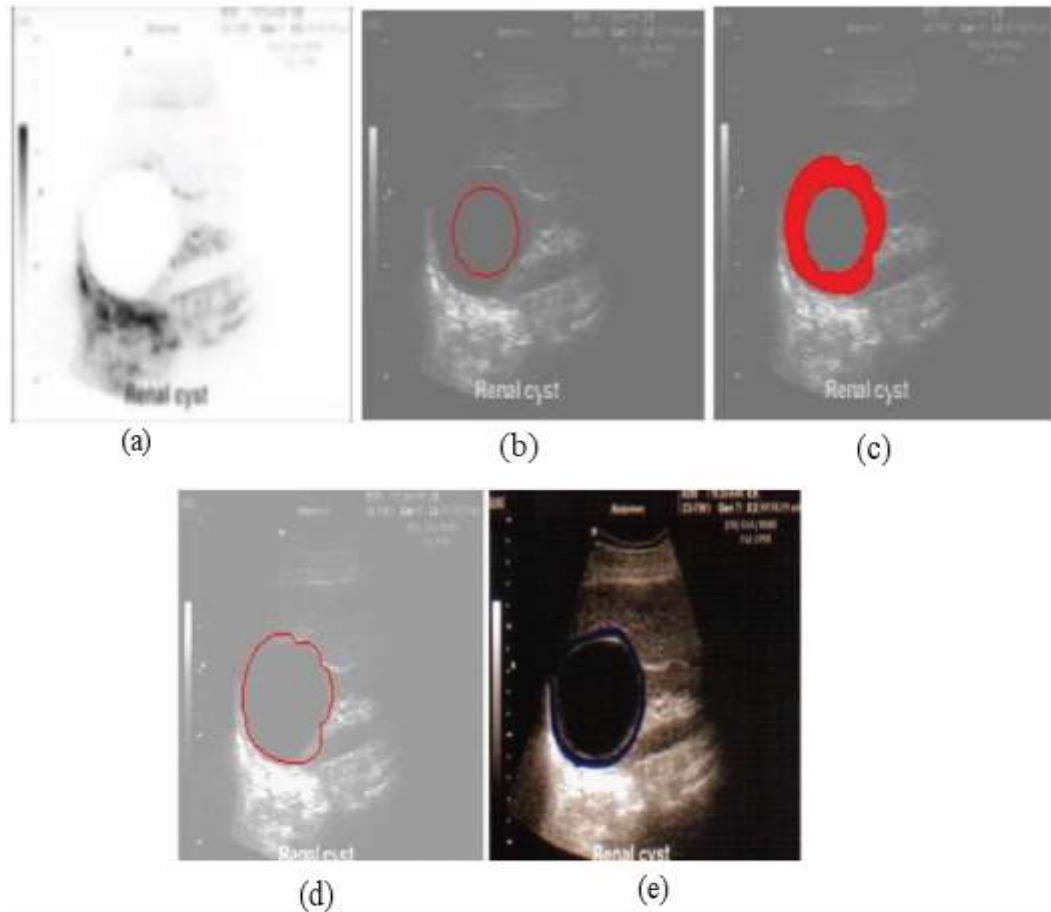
Segmentation of single-cystic kidney using GVF model: (a) Denoised single-cystic kidney ultrasound image (b) Predefined initial contour (c) Deformed intermediate image (d) Finally segmented image (e) Segmentation by a medical expert.
